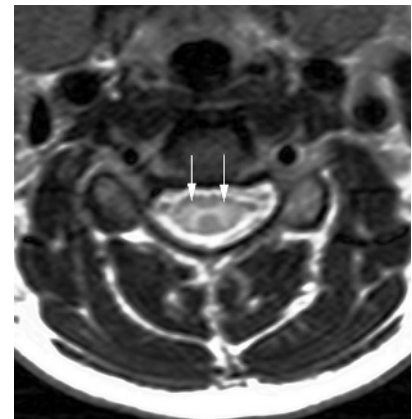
Axial T₂ weighted MRI of the spinal cord, showing a butterfly shaped high signal intensity of the grey matter (arrows).
